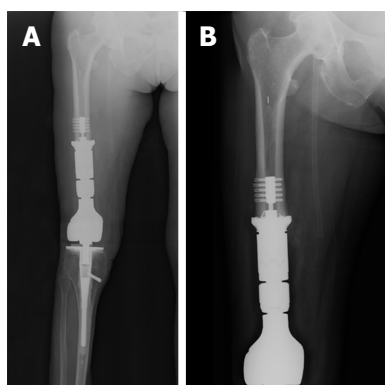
Postoperative radiographs showing the additional bone resection, resection of the soft tissue pseudotumor, and the definitive reconstruction with an extended femoral endoprosthesis. A: Four week post-operative radiograph showing resection of the distal 9 cm of femoral diaphysis and reconstruction with a 9 cm intercalary segment. The intercalary segment is secured to the femoral diaphysis with a femoral compress device (Zimmer Biomet, Warsaw, IN, United States); B: One-year postoperative radiograph showing distal femoral bone remodeling and bone integration into the porous end of the femoral compress device. The patient's thigh pain was completely resolved and her gait returned to a reciprocating smooth gait that appeared symmetrical to the contralateral leg.
